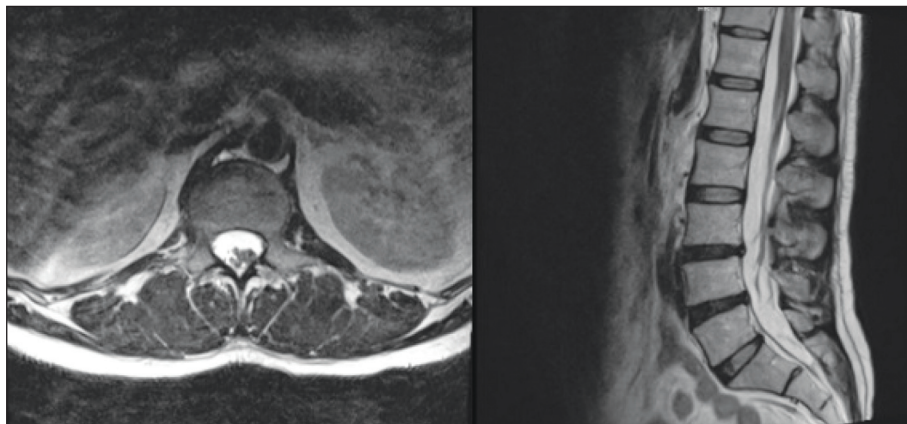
Postoperative 3th month control MRI
